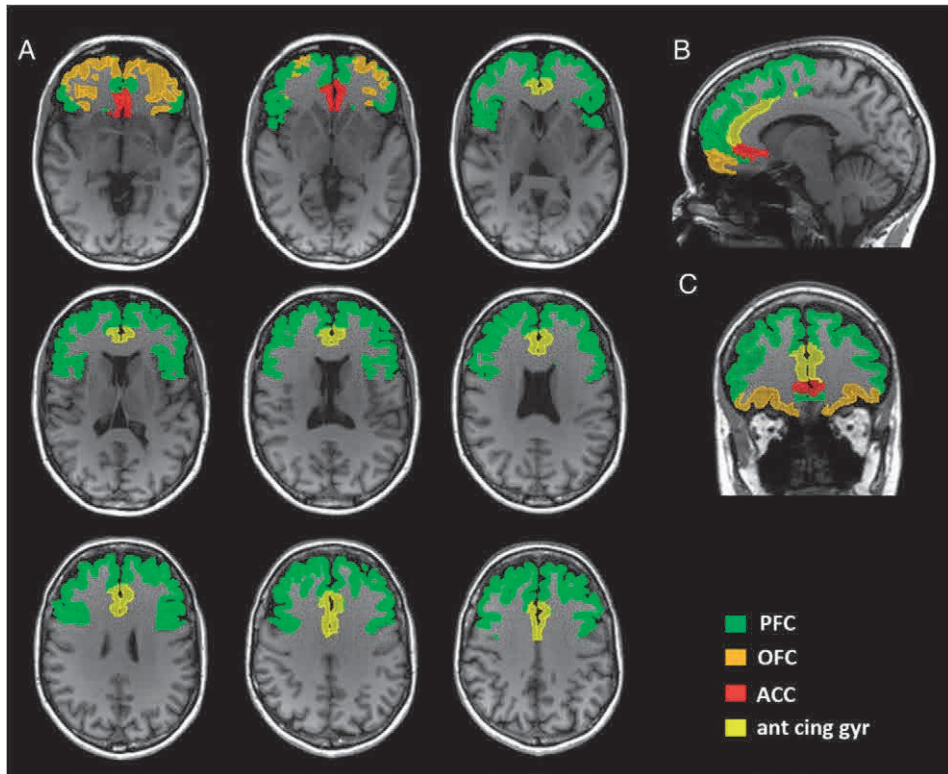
Masks for the frontal cortex. The mask is overlaid on a structural MRI scan and shown in transversal (A), sagittal (B), and coronal (C) views. MRI= magnetic resonance imaging; PFC= prefrontal cortex; OFC= orbitofrontal cortex; ACC= anterior cingulate cortex; ant cing gyr = anterior cingulate gyrus.
